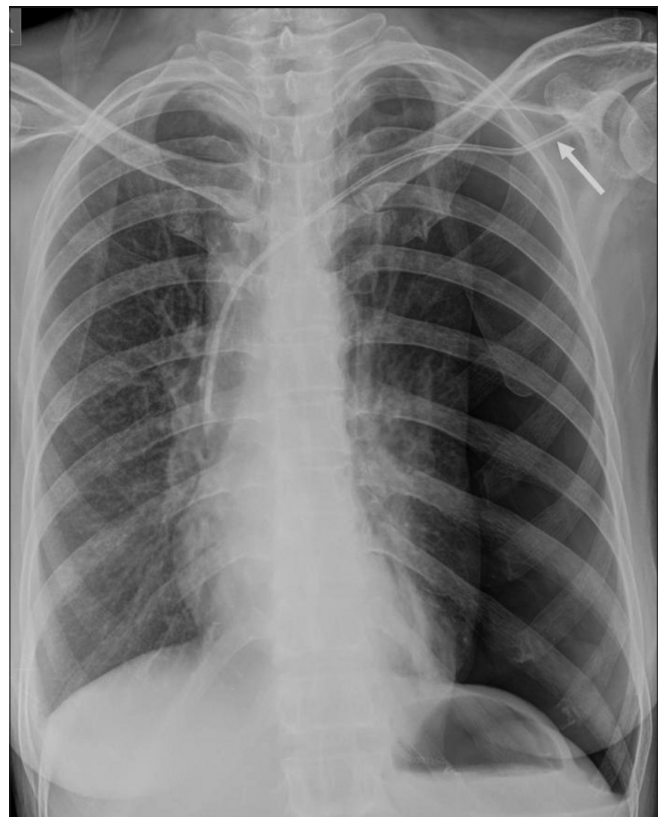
Frontal chest radiograph shows a left-sided pneumothorax following insertion of a central venous catheter. Note that the subclavian approach (arrow) was used for insertion of the catheter
